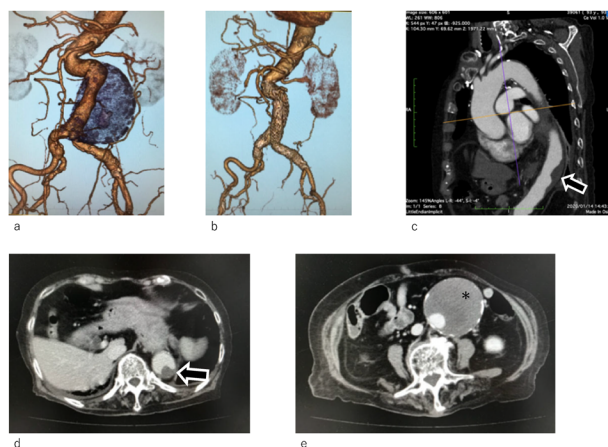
Pre- and postoperative computed tomography (CT) images: (a, b) Preoperative and postoperative enhanced CT three dimensional images. We successfully placed the stent-grafts as planned. (c–e) Preoperative CT images for analysis of the aorta. We observed a large thrombus in the descending aorta (arrow) and in the aneurysm(*).
